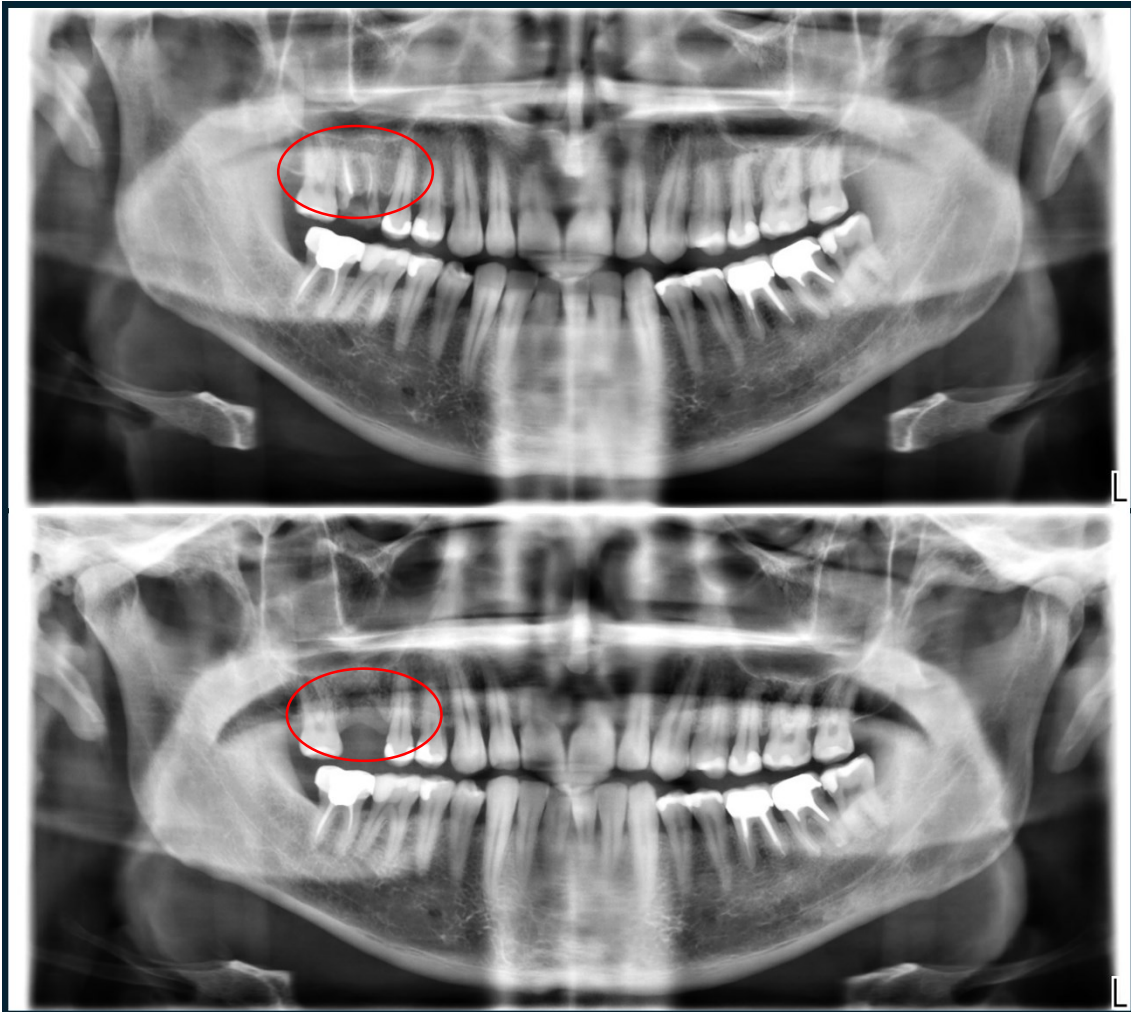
Patient SP6, orthopantomography comparison time 1 19/10/2023 (above), time 2 28/06/2024 (below)
